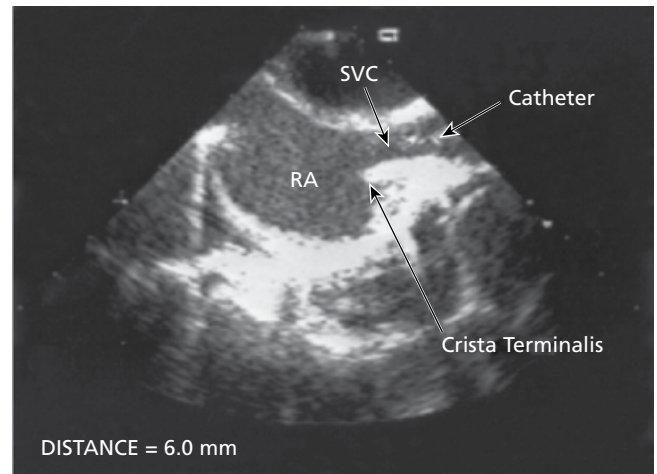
Transesophageal echocardiographic image of the superior vena cava (SVC)–right atrial (RA) junction in the sagittal plane in an infant. The tip of the right internal jugular catheter is in the SVC, 6 mm above the RA. Source: Reproduced with permission from Andropoulos et al [15] with permission of Wolters Kluwer.
